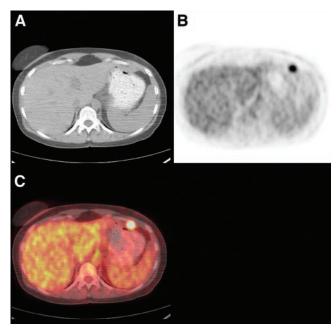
CT (A) was normal, but PET (B) and fused images (C) showed clear focus of intense tracer activity in left peritoneal cavity just anterior to stomach (on fused image but clearly not involving rib, as might be suspected from PET alone). This was focus of ovarian carcinoma. (Image courtesy C. Cohade and H. Pannu)
